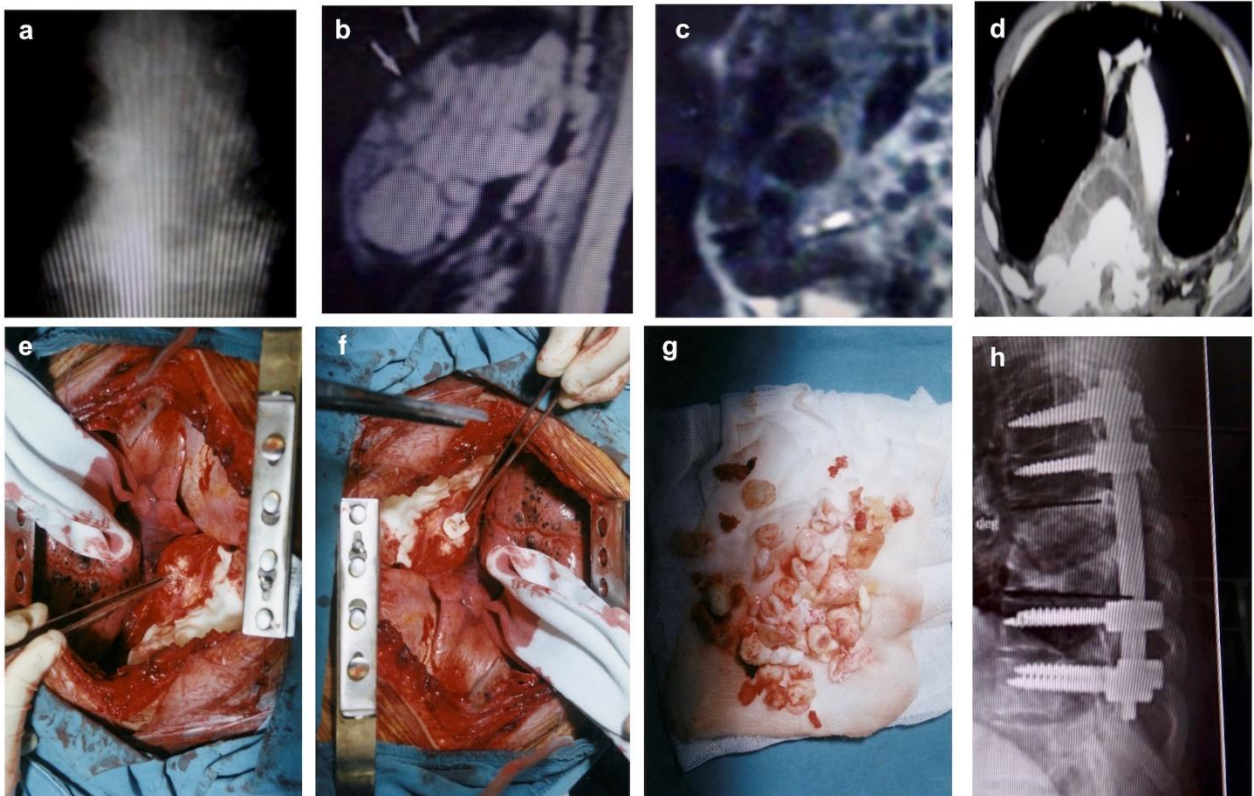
Preoperative X-ray (a), MR (b, c), and CT (d) images (e) of a 49-year-old male patient with a spinal hydatid cyst, who had an operation (e, f) in which the cysts were excised (g). Posterior instrumentation and fusion was performed at the T3–T8 level during the second session of surgery (h).
